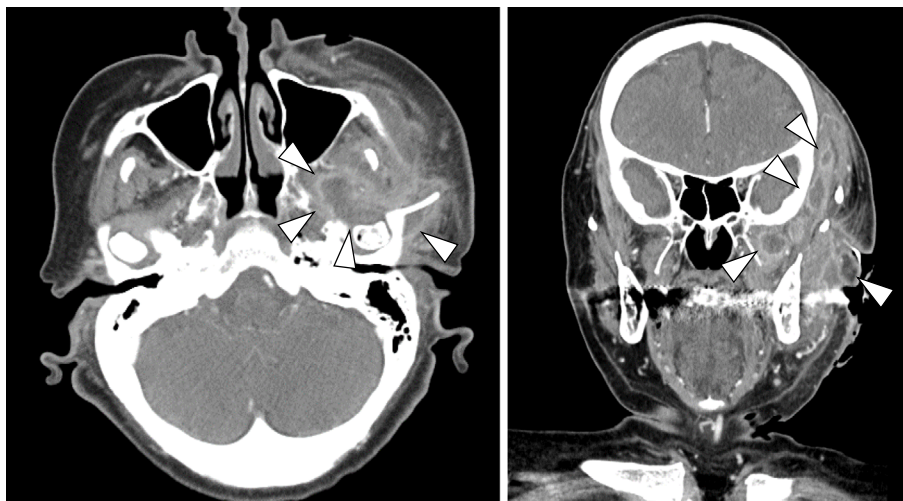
Contrast-enhanced computed tomography of the face. Axial (A) and coronal (B) views demonstrating multiple deep-seated abscesses.
